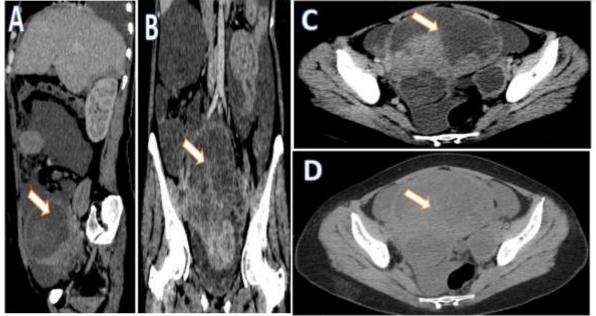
(Mme N.B) : Thoracic-abdominal-pelvic CT C-/C+ :Large heterogeneous abdominal-pelvic mass with predominantly suprasternal tissue (arrow) A A:sagittal section B :coronal section C,D :axial sections with and without contrast injection Discussion:
